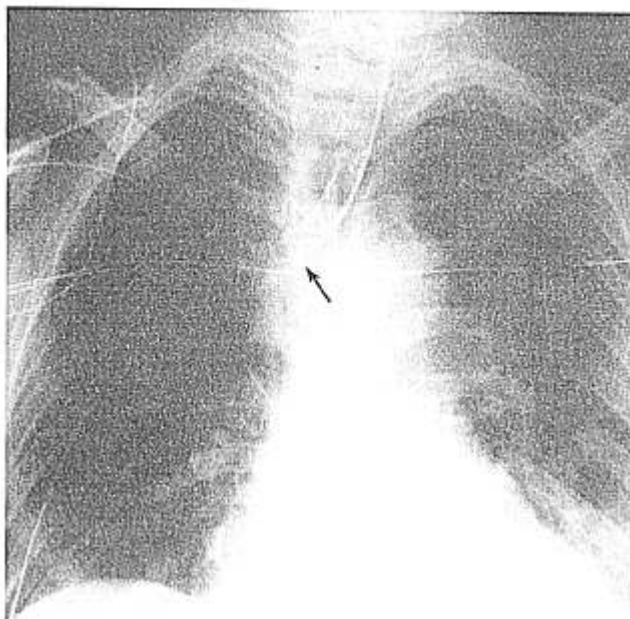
Chest roentgenogram after successful nasotracheal intubation with the Endotrol™ tube. Note the severe arcing of the tube within the trachea.
